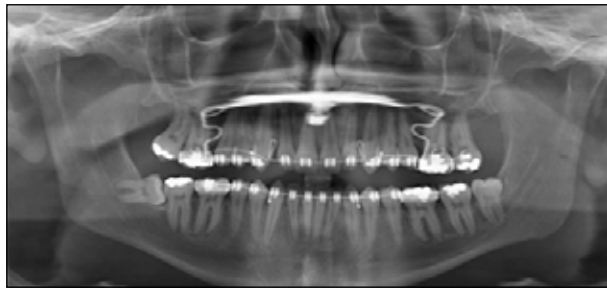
Panoramic radiograph showing good bodily distalisation of the upper first molars.
